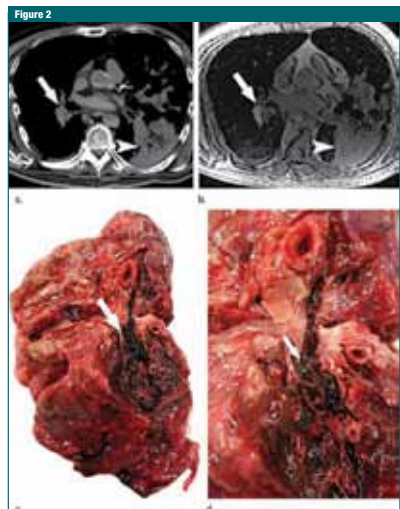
Pulmonary embolus as a major finding, directly related to the cause of death, in a 62-year-old man with history of melanoma and central vascular disease who was admitted to hospital with acute respiratory insufficiency. (a) Postmortem axial CT and (b) T1-weighted MR images demonstrate a consolidation in the left lung (arrowhead). A pulmonary embolus (arrow) is clearly visualized at MR but not depicted at CT. (c, d) CA confirmed pulmonary embolus (arrow) as a major finding directly related to the cause of death.
